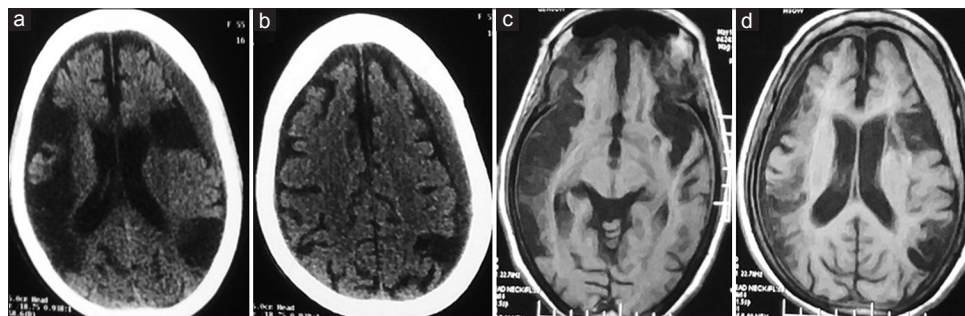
(a and b) Noncontrast computed tomography scan showing left posterior frontal, temporo-parietal, and right posterior frontal and posterior parietal gliotic changes with diffuse cerebral atrophy. Note the chronic subdural hematoma on the left fronto-temporo-parietal region. (c and d) T1-weighted magnetic resonance imaging showing the same gliotic changes with the left hemispheric chronic subdural hematoma without any midline shift. The sulci and gyri on the left side are not compromised due to the hematoma
